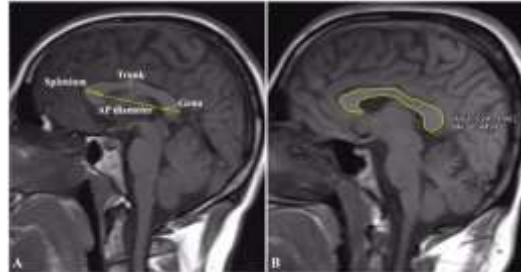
The measurements of the corpus callosum (CC) on sagittal T1-weighted MRI. Fig. 1A shows the anterior-posterior diameter, genu, trunk, and splenium measurements. Fig. 1B shows the CC area on the same plane. It is calculated automatically with a closed-line manual drawn around the CC.
